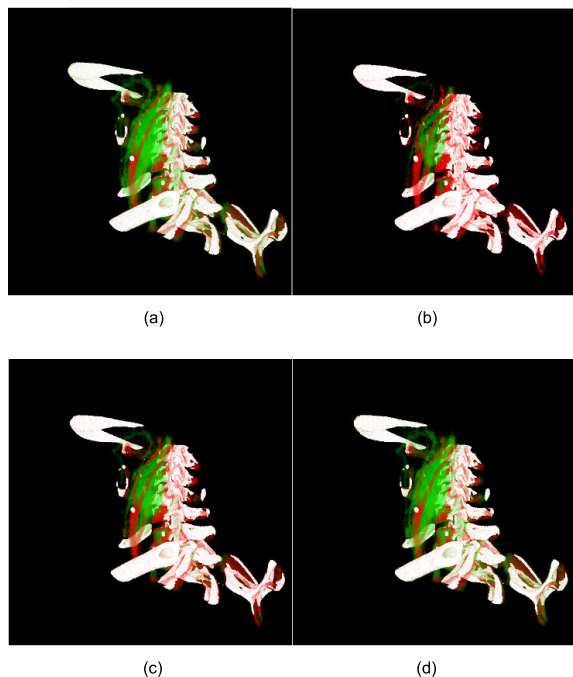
Renderings of CT Neck dataset in our system. Green represents thyroid tumor, red represents carotid arteries, and white represents bone. (a) shows the most possible appearance for thyroid tumor, carotid arteries and bone in the MaxProbView. (b)-(d) show thyroid tumor's three probability query results (from left to right, the thyroid tumor's probabilities are 99%, 90% and 50%, respectively) in the ExplicitProbView.
